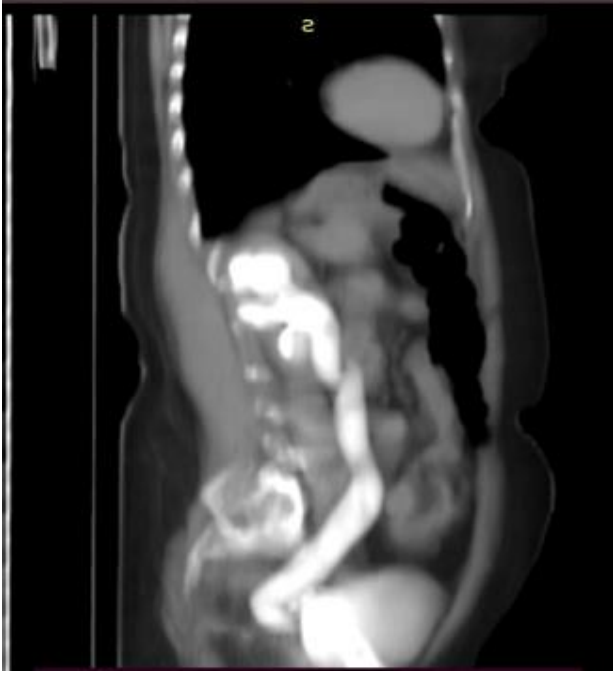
CT scan of left distal ureteral block with ureter nephrosis.
